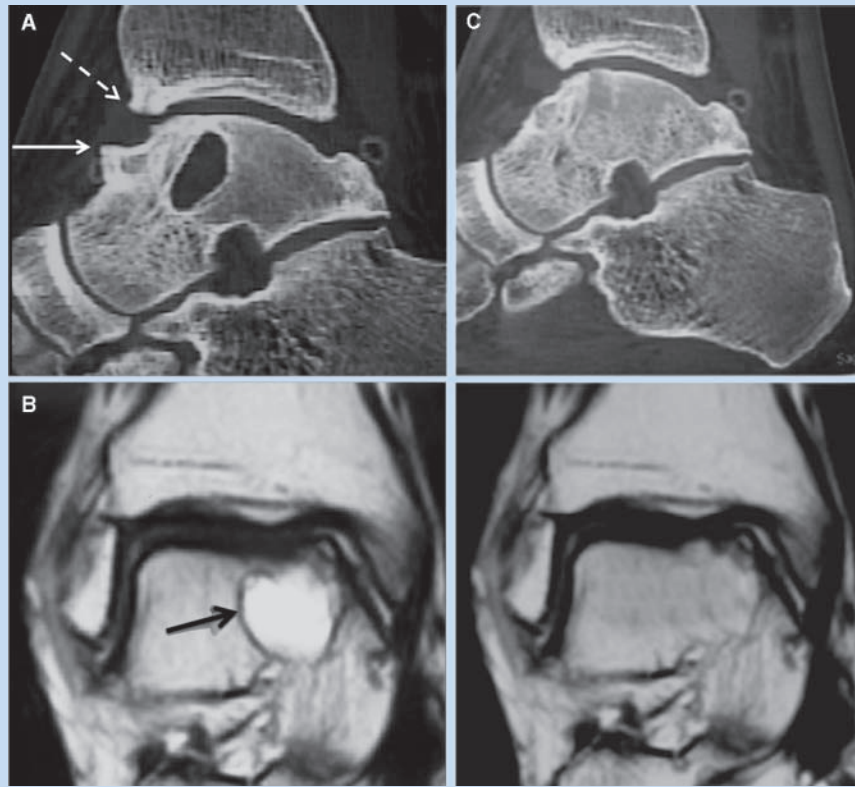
A, sagittal computed tomography image of a young man with a large cystic osteochondritis dissecans of the medial talus and large medial impingement spurs: talar spur (solid arrow) and tibial spur (broken arrow). B, semicoronal computed tomography image of the large medial osteochondritis dissecans lesion (arrow). C, the cyst was bone grafted, and the large impingement spurs were removed with uneventful healing. (Images courtesy of Mark S. Myerson, MD)
